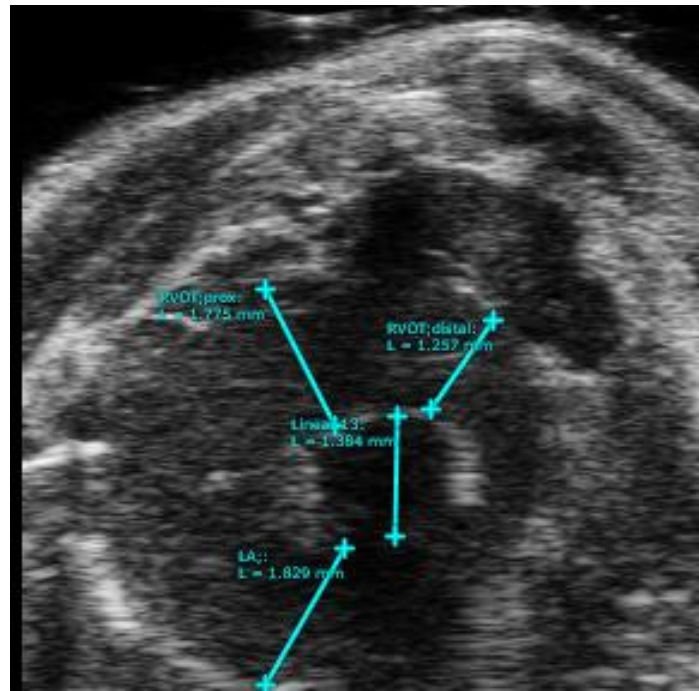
2D of Parasternal short-axis view, at aortic valve level.
